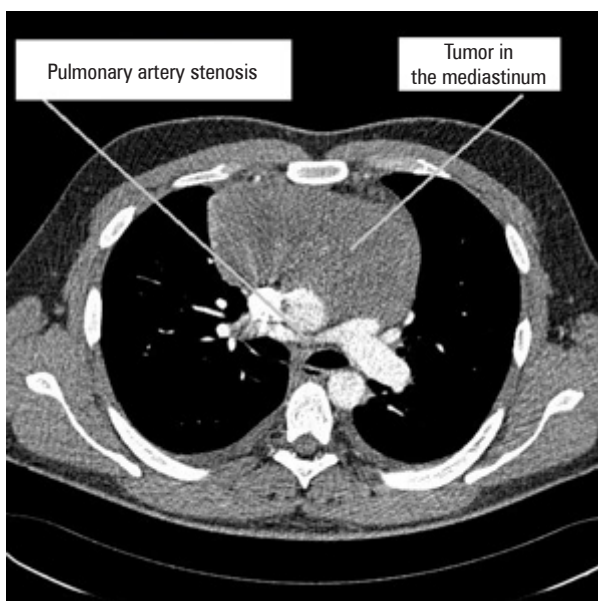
Computed tomography: pulmonary artery stenosis due to tumor in the mediastinum
